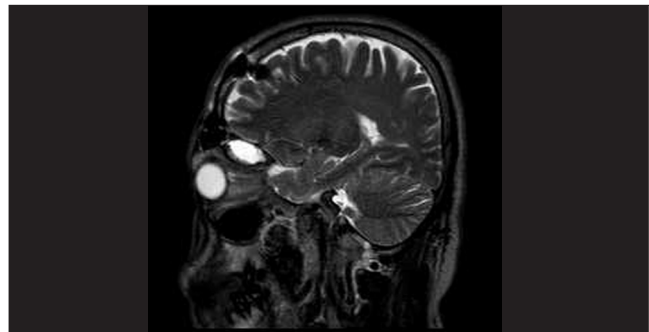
Sagittal MR imaging demonstrating that the lesion is smaller after the operation
